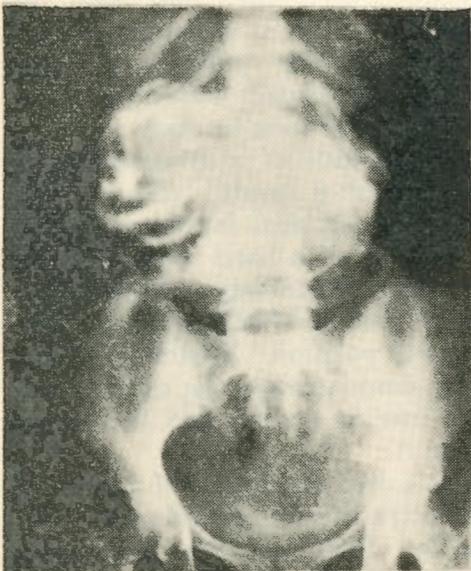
X-ray photograph taken at the time of admission on 17-2-54. Note the bizarre position of the foetus and the circumscribed dark shadow below.
